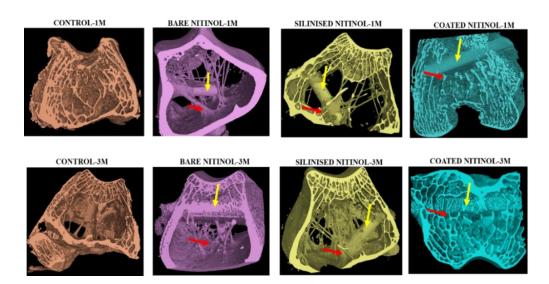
Radiographic 3D images of defect bone sites showing extent of healing after 1month and 3 month (Red arrow showing new bone growth around the implant; yellow arrow showing implant material)
